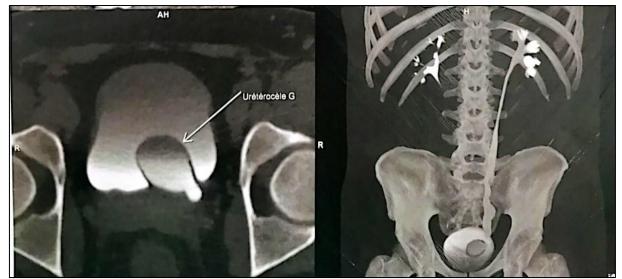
Abdominal-pelvic CT scan showing a left ureterocele complicated by an 11 mm long iliac ureter stone with left pyeocalic dilatation
